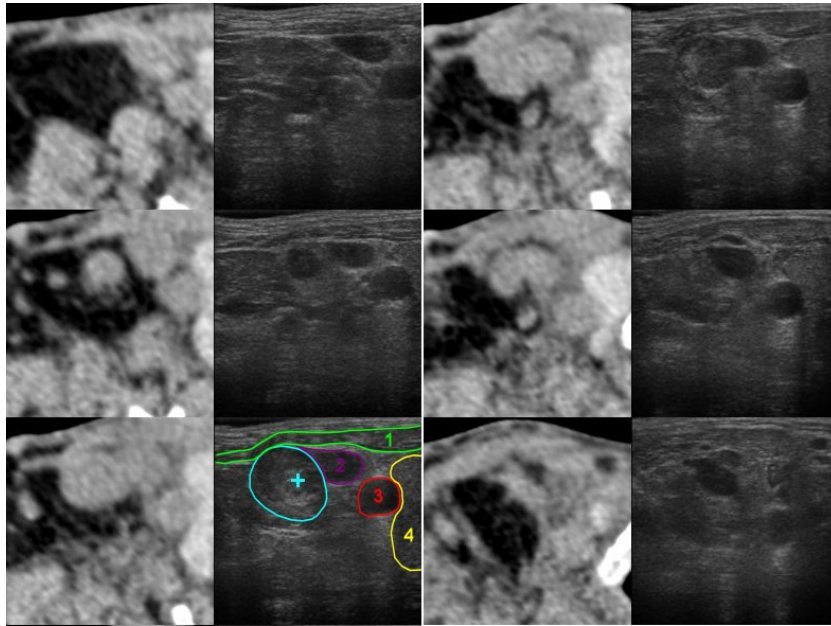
Images used for registration from Patient 4, 6 consecutive ultrasound and CT slice pairs; a malignant target lymph node (blue outline and TRE cross; 1-sternocleidomastoid muscle, green, 2-internal jugular vein, purple, 3-carotid artery, red, 4-thyroid, yellow)
